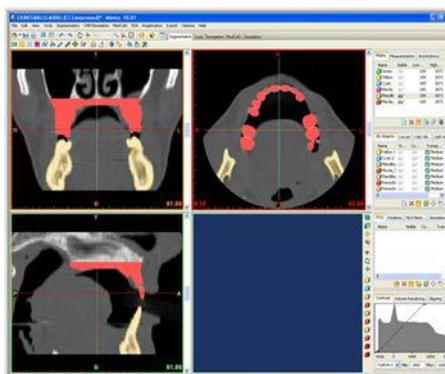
3D reconstruction of the anatomical reference point in the analyzed CT scan
